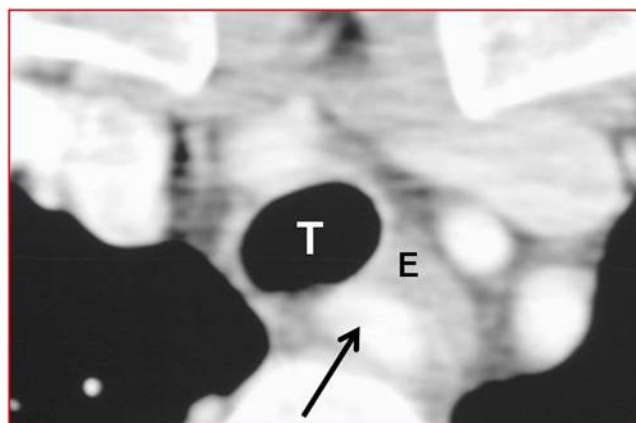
Axial contrast-enhanced CT image showing the aberrant right subclavian artery (arrow) coursing posteriorly and compressing the esophagus (E). The structure labelled T is the trachea.
